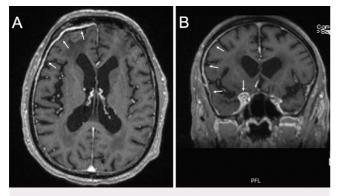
T1-weighted post-gadolinium MRI scans of the brain in axial (A) and coronal (B) sections demonstrating diffuse right-sided dural enhancement (*arrows*).
